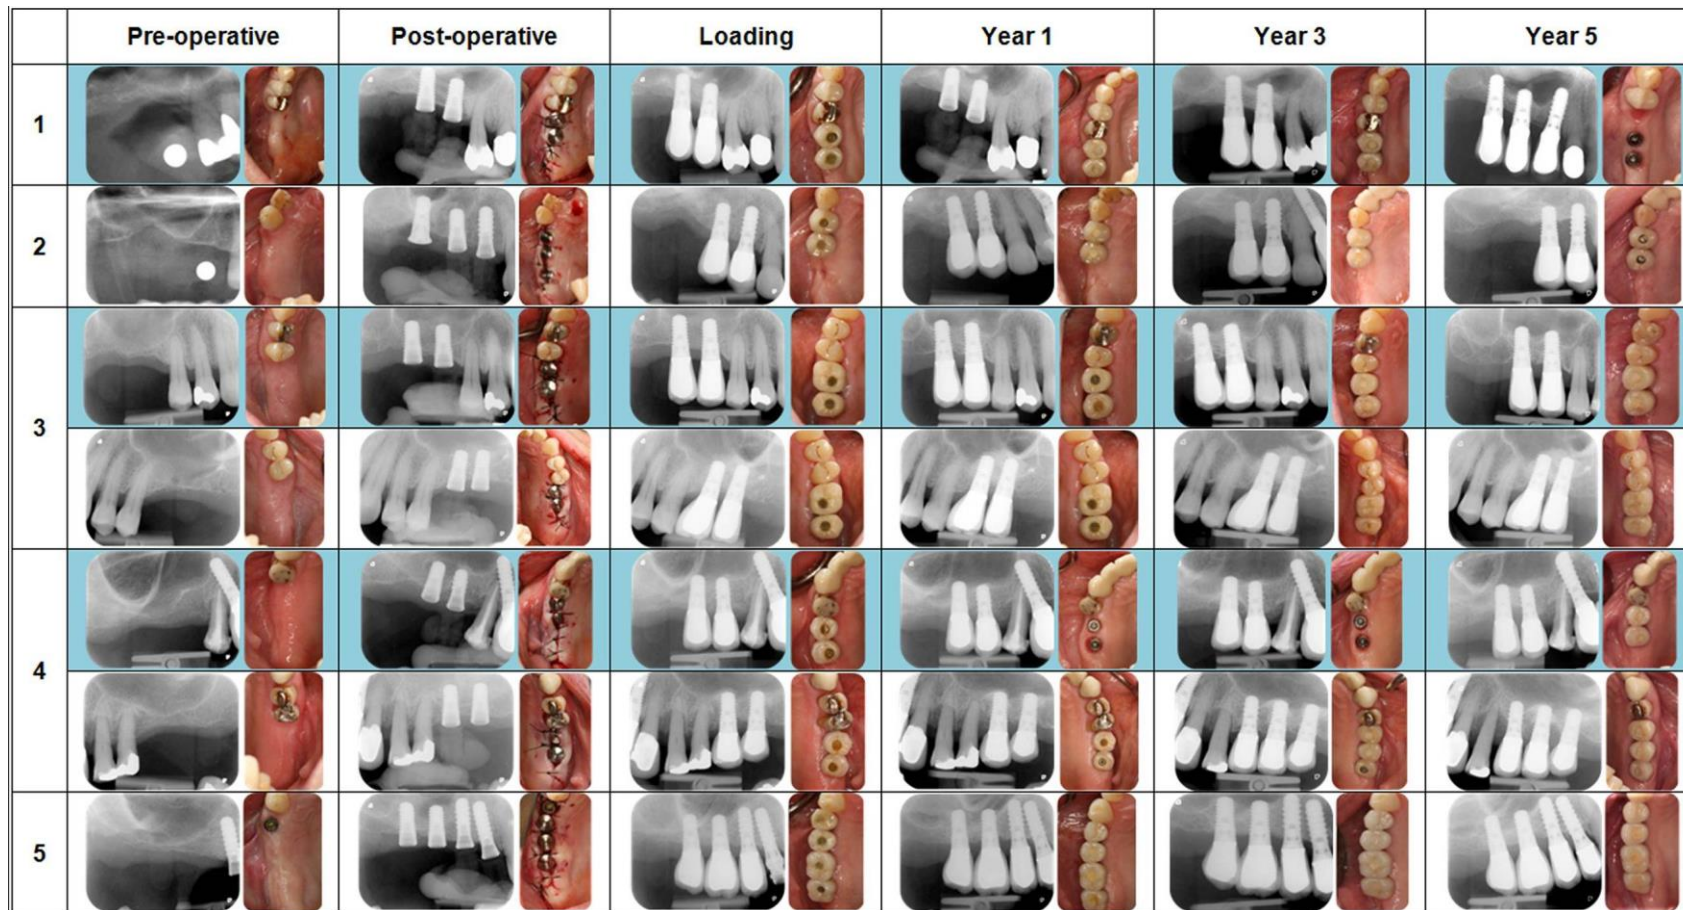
Evolution of sinus floor level over 5 years. Radiographs and clinical photographs of cases 1-5.
